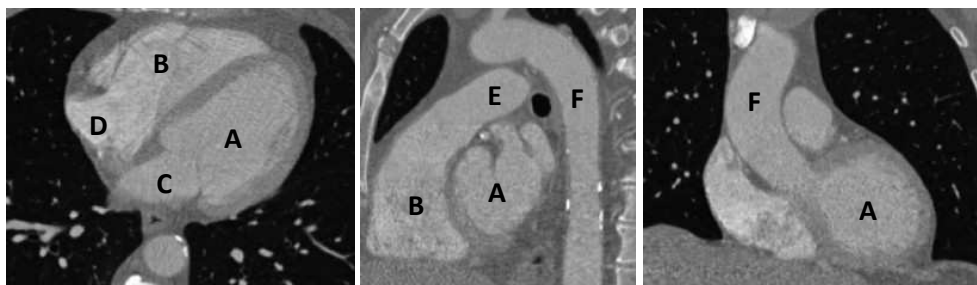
Different views of a 3D CT image of the heart. A- Left ventricle, B- Right ventricle, C- Left atrium, D- Right atrium, E- Pulmonary artery, F- Aorta.
